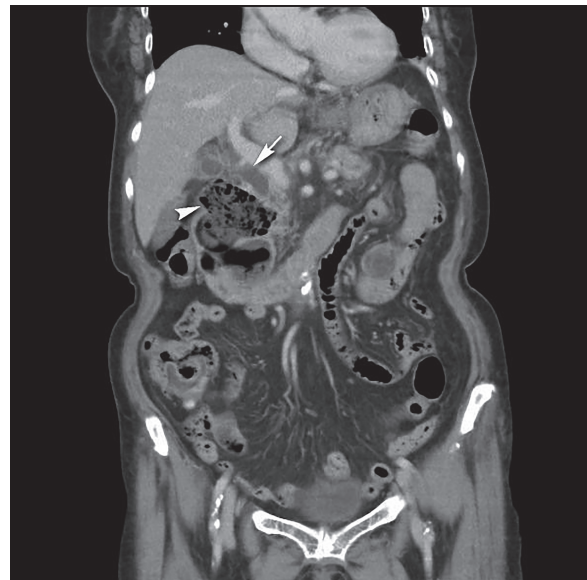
Abdominal computed tomography (CT) showed a huge juxtapapillary diverticulum (arrowhead) and dilatation of the common bile duct (arrow).
